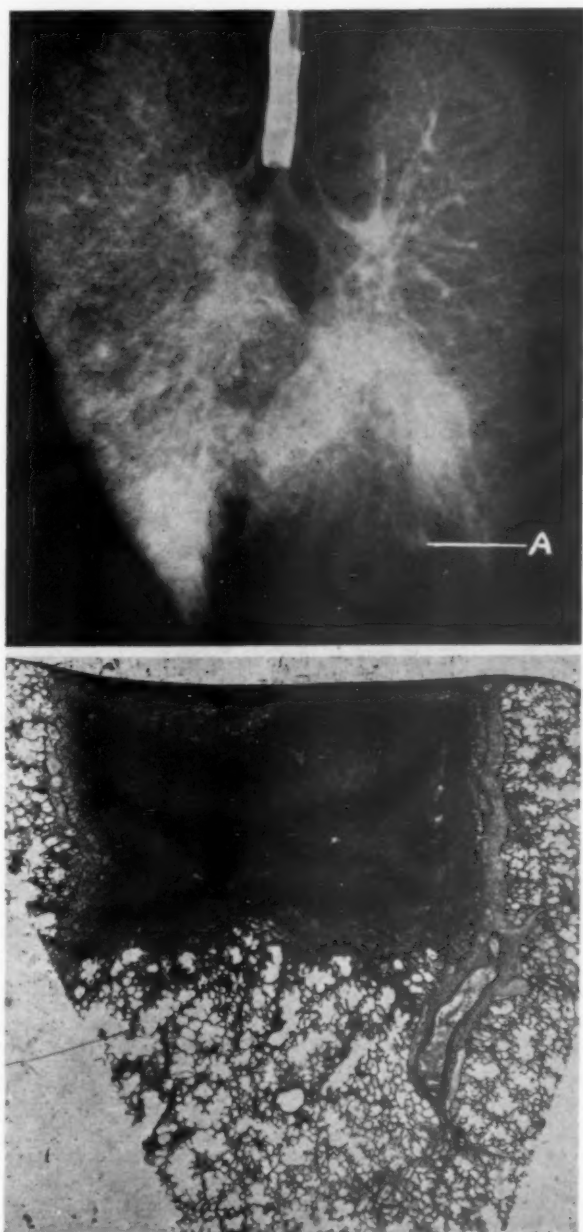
Above:* Roentgen-ray of the lungs of a case of mitral stenosis showing general thickening of all bronchi. *A.* Limited density beneath diaphragmatic pleura indicating exudate and infiltration.
